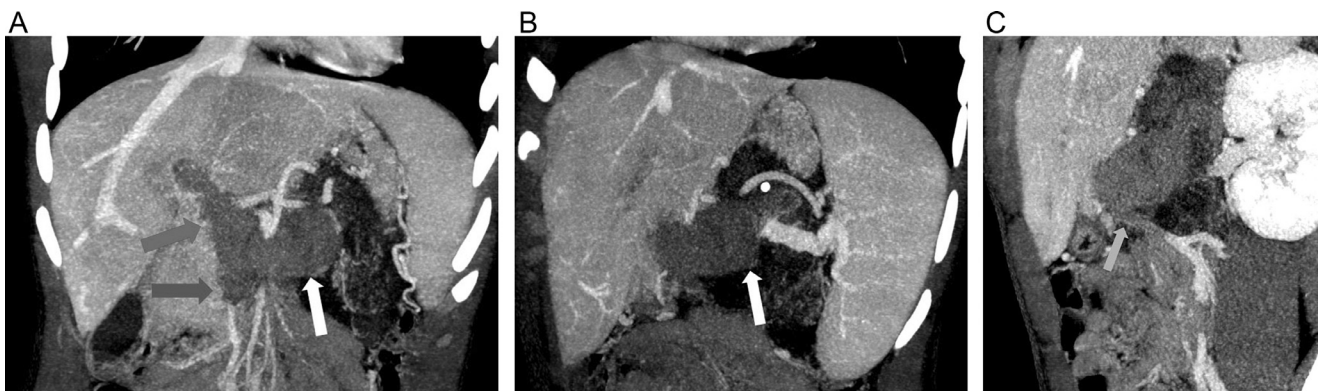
(A–C) Contrast-enhanced portal phase CT scan: The coronal MIP images depicts a large venous aneurysm with a superimposed massive thrombosis involving the portal vein (red arrow), the superior mesenteric vein (blue arrow), the splenic vein (white arrow), and the inferior mesenteric vein (green arrow). Enlarged spleen is also observed (Color version of the figure is available online.)
